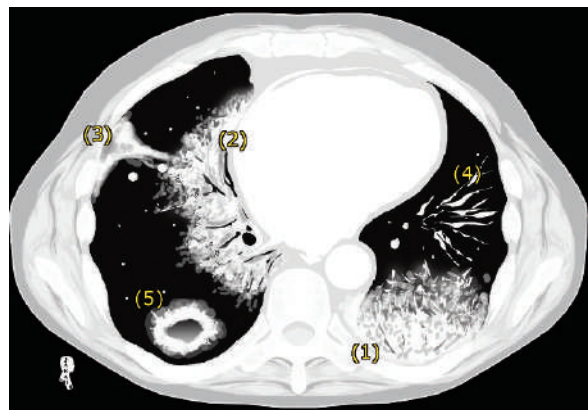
Axial thoracic ling-window HRCT demonstrates the different manifestations of COP: (1) peripheral classical patchy infiltration of COP, (2) bronchogenic COP, (3) bronchocentric COP, (4) thickened interlobar septae, and (5) Atoll sign
